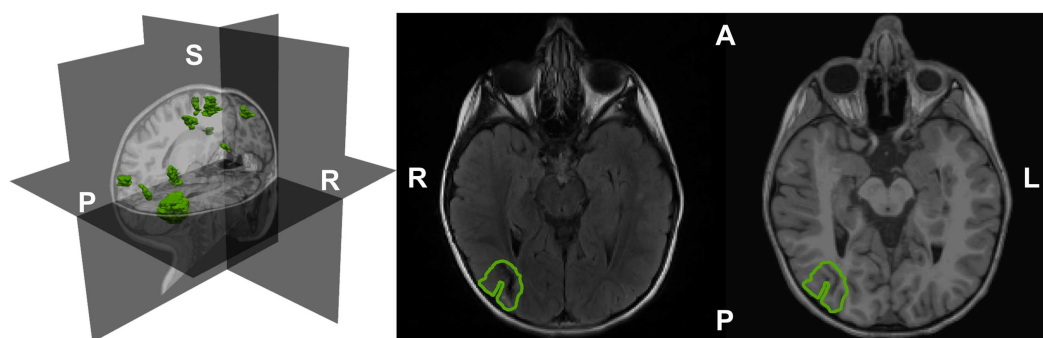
The segmented and rendered tubers (in green) of the epilepsy TSC patient shown in a 3D head representation based on T1-weighted MRI data (left). Tuber outline axial on T2 (center) and T1-weighted MRI images (right). A: anterior; L: left; P: posterior; R: right; S: superior.
